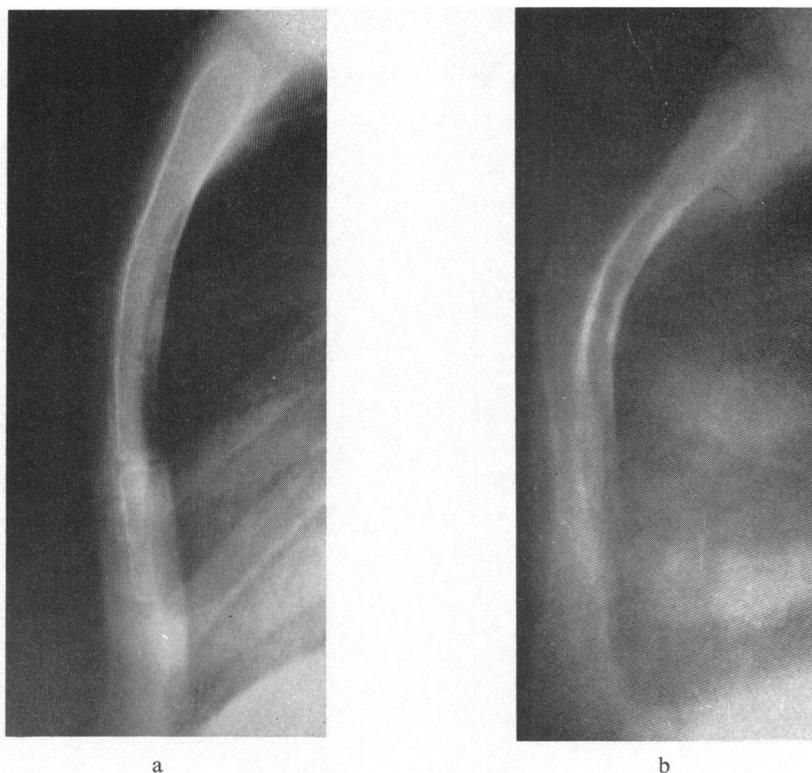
X-ray of sternum, showing fusion of the manubrium and body of the sternum; (a) in Case 2 at 5 years of age, and (b) in Case 3 at 4 years of age.
